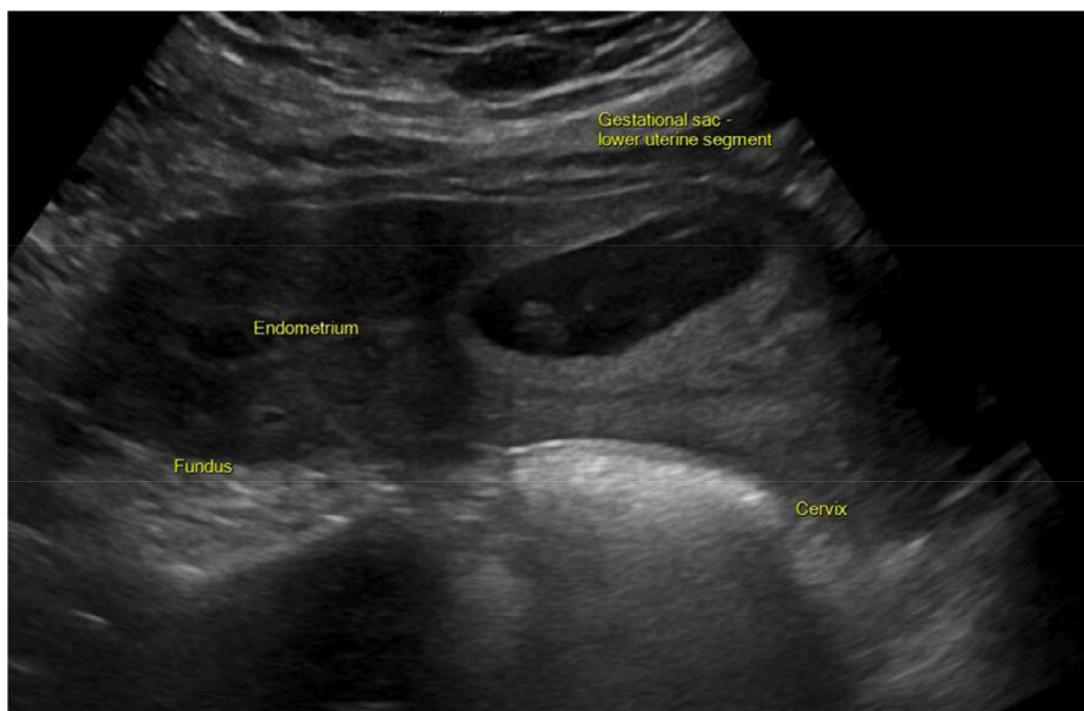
Sagittal transabdominal ultrasound demonstrating the characteristics of cesarean scar ectopic pregnancy: Low, anterior implantation of the gestational sac, absence of cervical involvement, extension toward the endometrium, and lack of normal endometrial cavity location.
